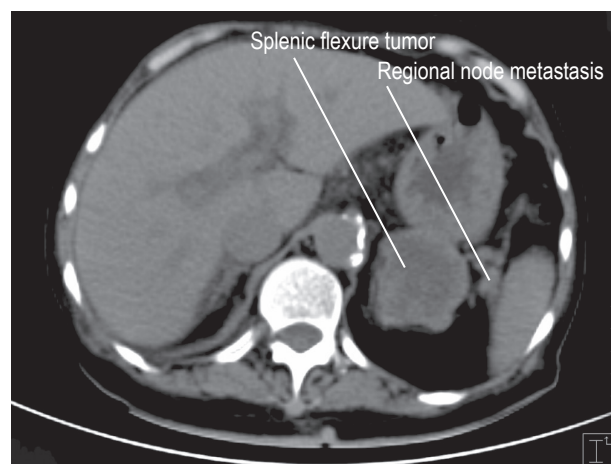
False negative CT. This case of primary CA Splenic flexor, only CT study shows no demonstrated regional node enlargement.
